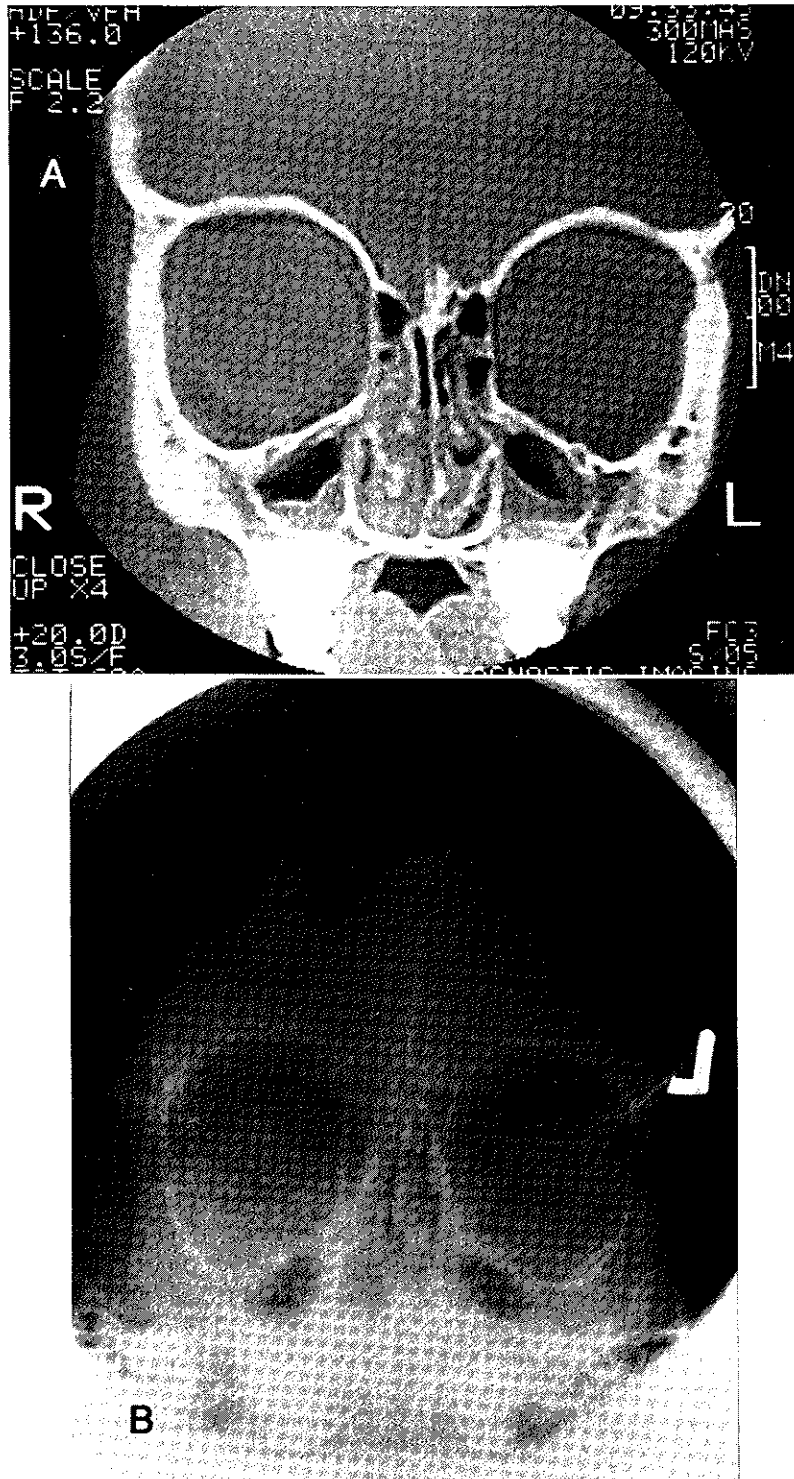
A, CT scans delineate inaccessible anatomic structures and demonstrate disease not shown on B, routine x-ray films.
